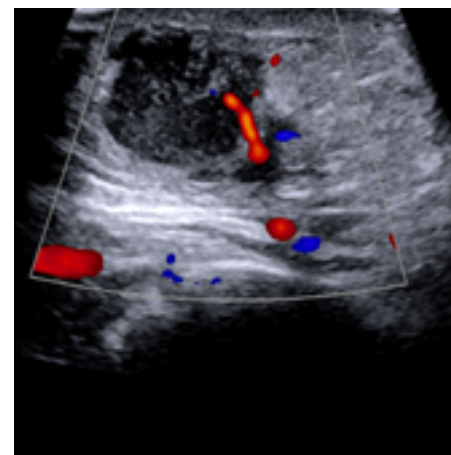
Ultrasound of Left Upper Extremity.
